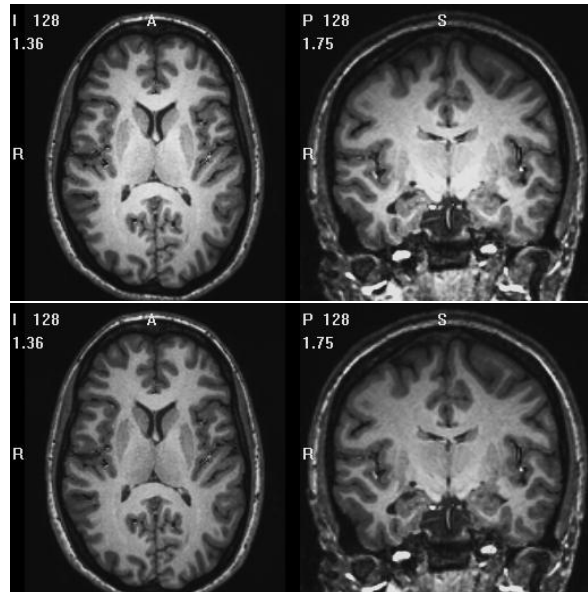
2. Before (upper row) and after (lower row) N3 intensity correction for one MR image.
